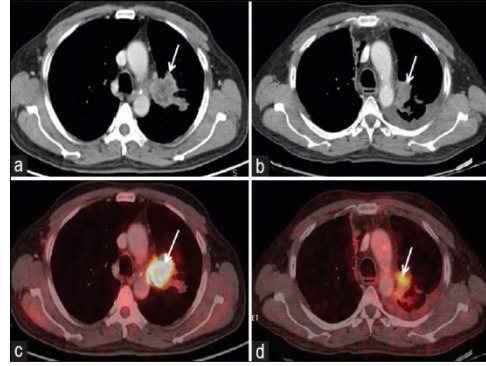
shows Concordance on metabolic and morphological imaging. There is significant reduction in size (1a and, b - arrow) and metabolic activity (max SUV) (1c, and d - arrow) seen on both axial CT component and axial fused PET/CT component, respectively; thus, partial response (PR) on ResponseEvaluation Criteria in Solid Tumor (RECIST) is concordant with partial metabolic response (PMR), according to European Organization for Research and Treatment of Cancer (EORTC) criteria ⁽¹²⁾.
